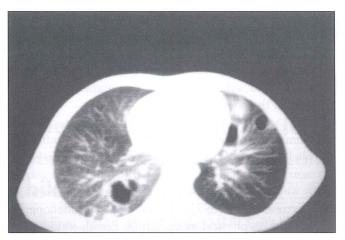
Chest X-ray on admission showing bilaterally lung abscess, pneumatoceles and patcy areas of consolidation.
